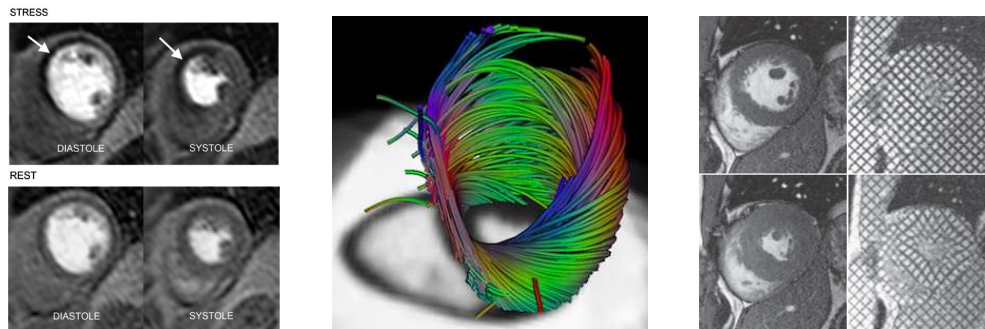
Left: Cardiac MR perfusion imaging with stress testing on a patient with subtotal occlusion of the left anterior descending artery. White arrows indicate stress perfusion defects [Motwani et al., 2012]. Centre: Left ventricle muscle fibers extracted using image analysis on DTMRI images. Right: Tagged MRI. Motion of the heart can be tracked from MR image sequences through tagged MR imaging. <http://www.nature.com/nrcardio/journal/v6/n12/thumbs/nrcardio.2009.189-f1.jpg>
